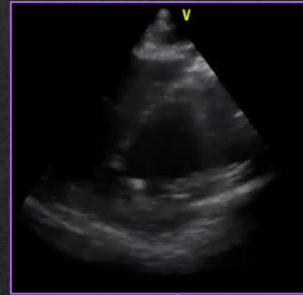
parasternal short axis (PSAX) view.
